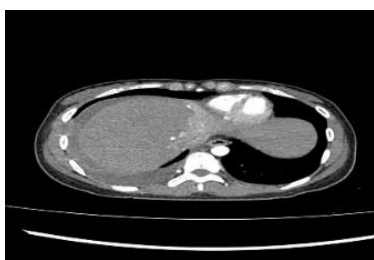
Axial CT Scan showed blushing of contrast at segment 4 liver injury
